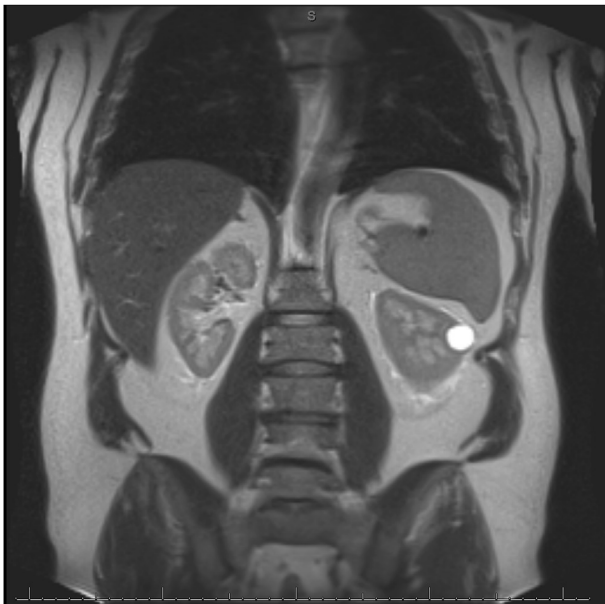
T2 weighted MRI of the abdomen showing a Bosniak 2F cyst.
